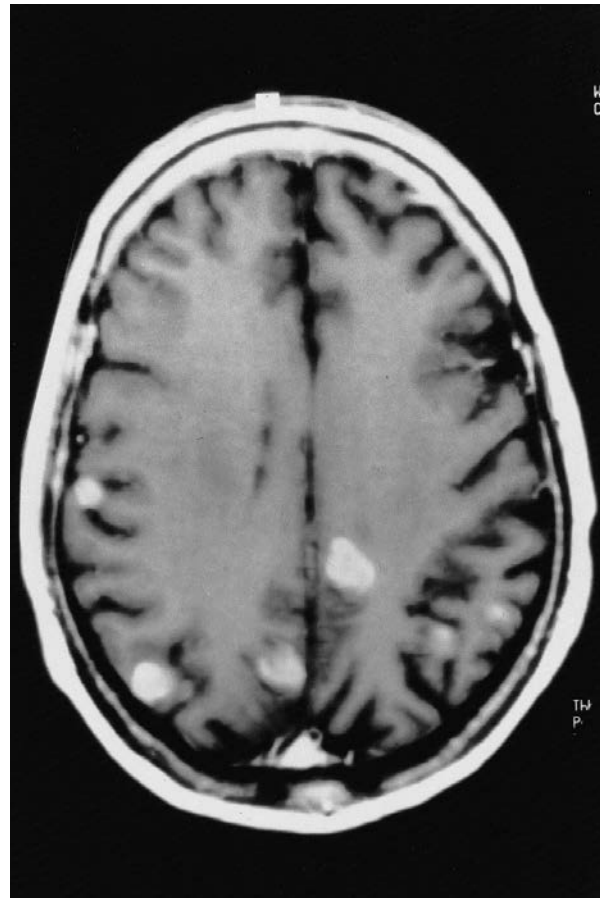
T1 gadolinium-enhanced MRI of a patient with multiple enhancing brain metastases.
